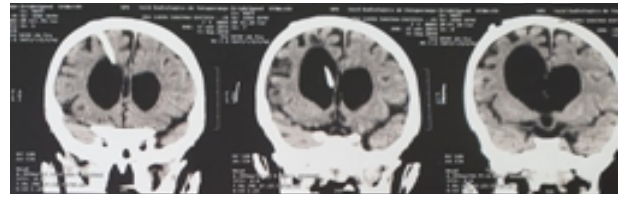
Pre-operative cranial computed tomography in sagittal section demonstrating hydrocephalus and proximal catheter inside ventricular system
